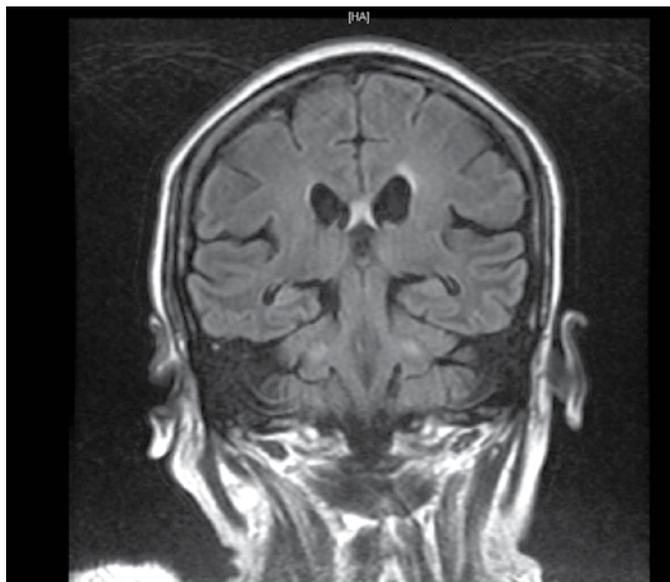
Magnetic resonance imaging scan of the brain (FLAIR image) showing faint signal in bilateral middle cerebellar peduncles on coronal view.
